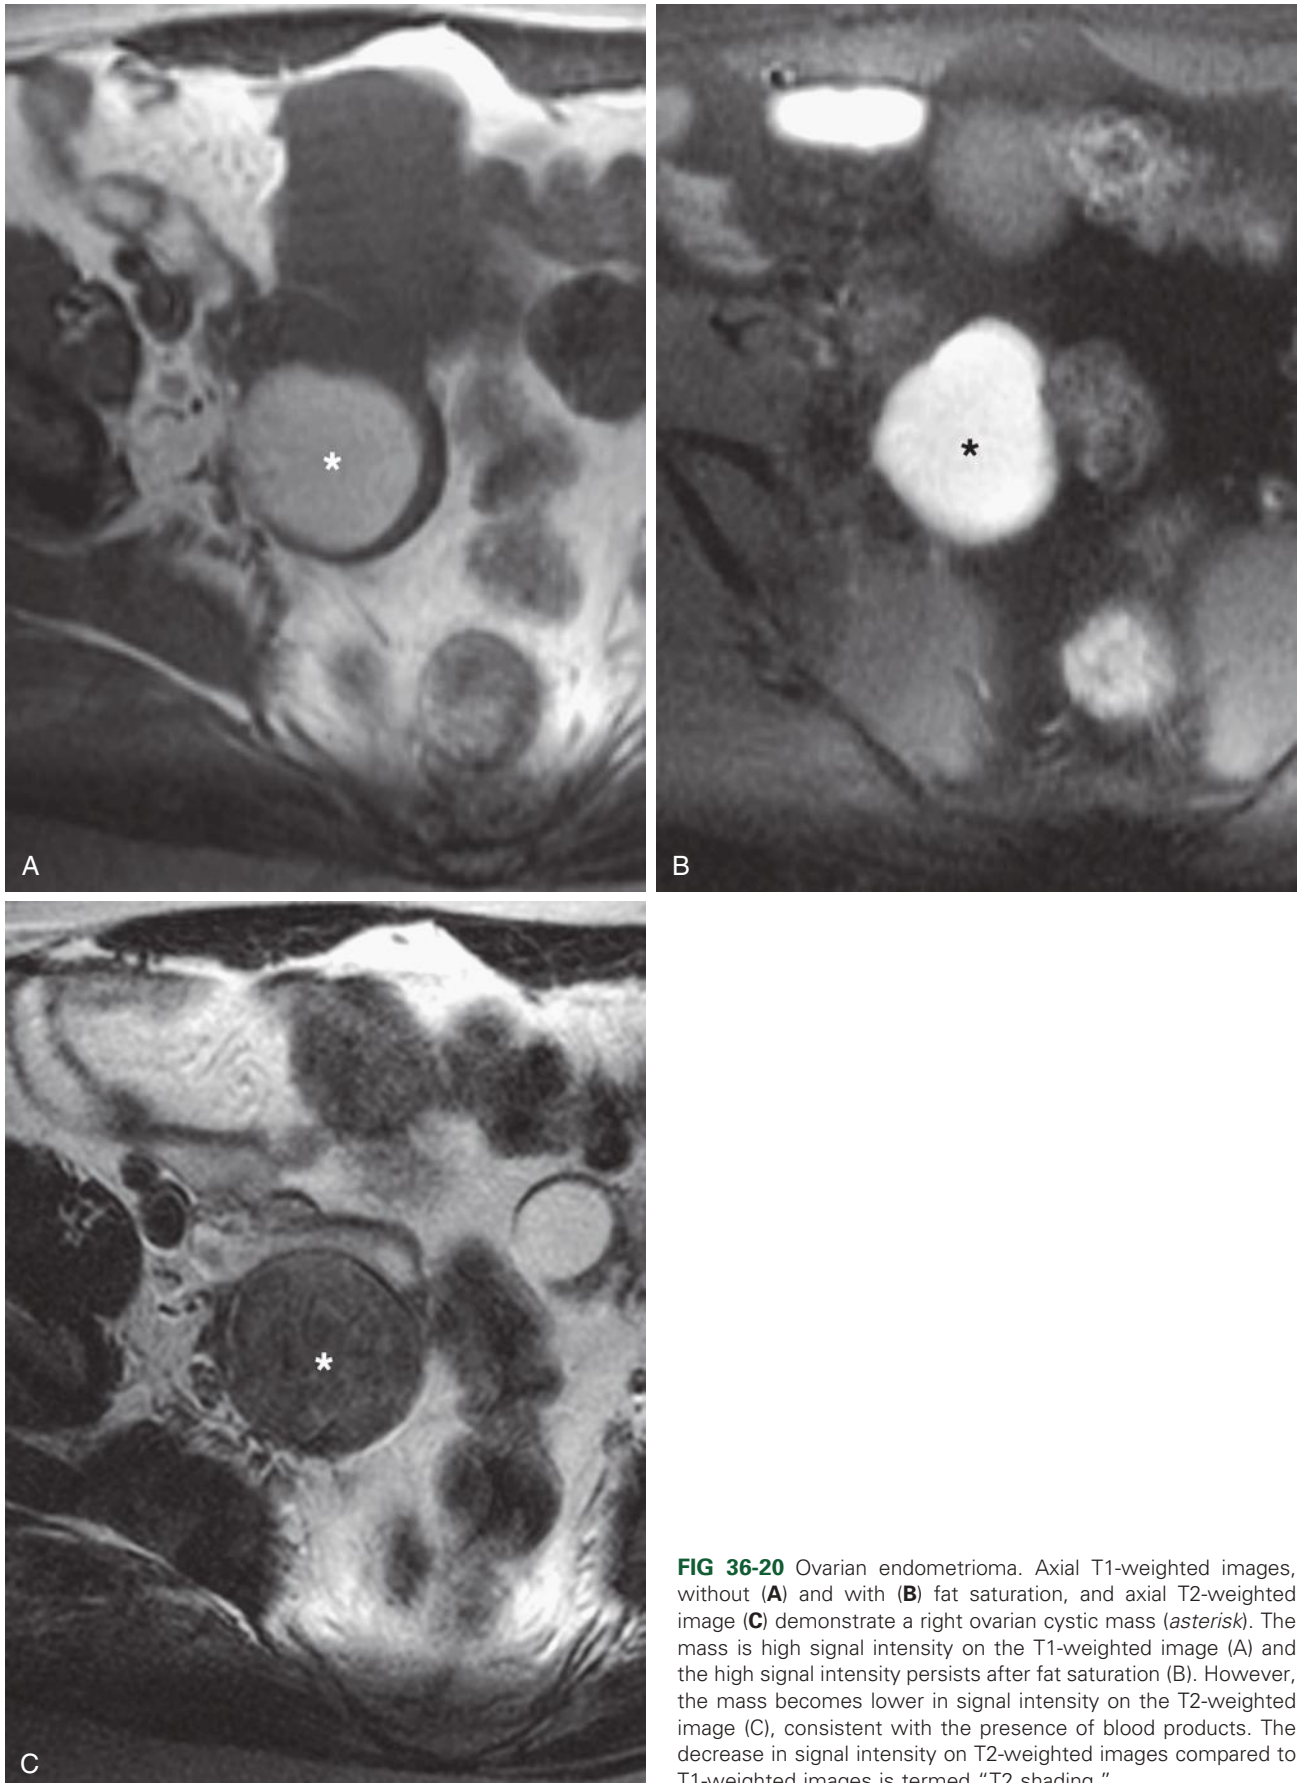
Ovarian endometrioma. Axial T1-weighted images, without (A) and with (B) fat saturation, and axial T2-weighted image (C) demonstrate a right ovarian cystic mass (*asterisk*). The mass is high signal intensity on the T1-weighted image (A) and the high signal intensity persists after fat saturation (B). However, the mass becomes lower in signal intensity on the T2-weighted image (C), consistent with the presence of blood products. The decrease in signal intensity on T2-weighted images compared to T1-weighted images is termed “T2 shading.”
